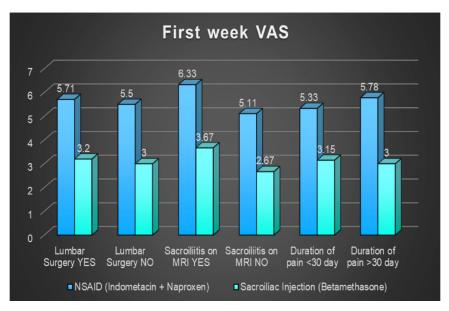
VAS scores at the first week after treatment are shown according to whether or not lumbar surgery was performed, whether there was sacroiliitis, and the duration of pain. VAS: Visual Analogue Scale, NSAID: Nonsteroidal anti-inflammatory drug, MRI: Magnetic resonance Imagining.
